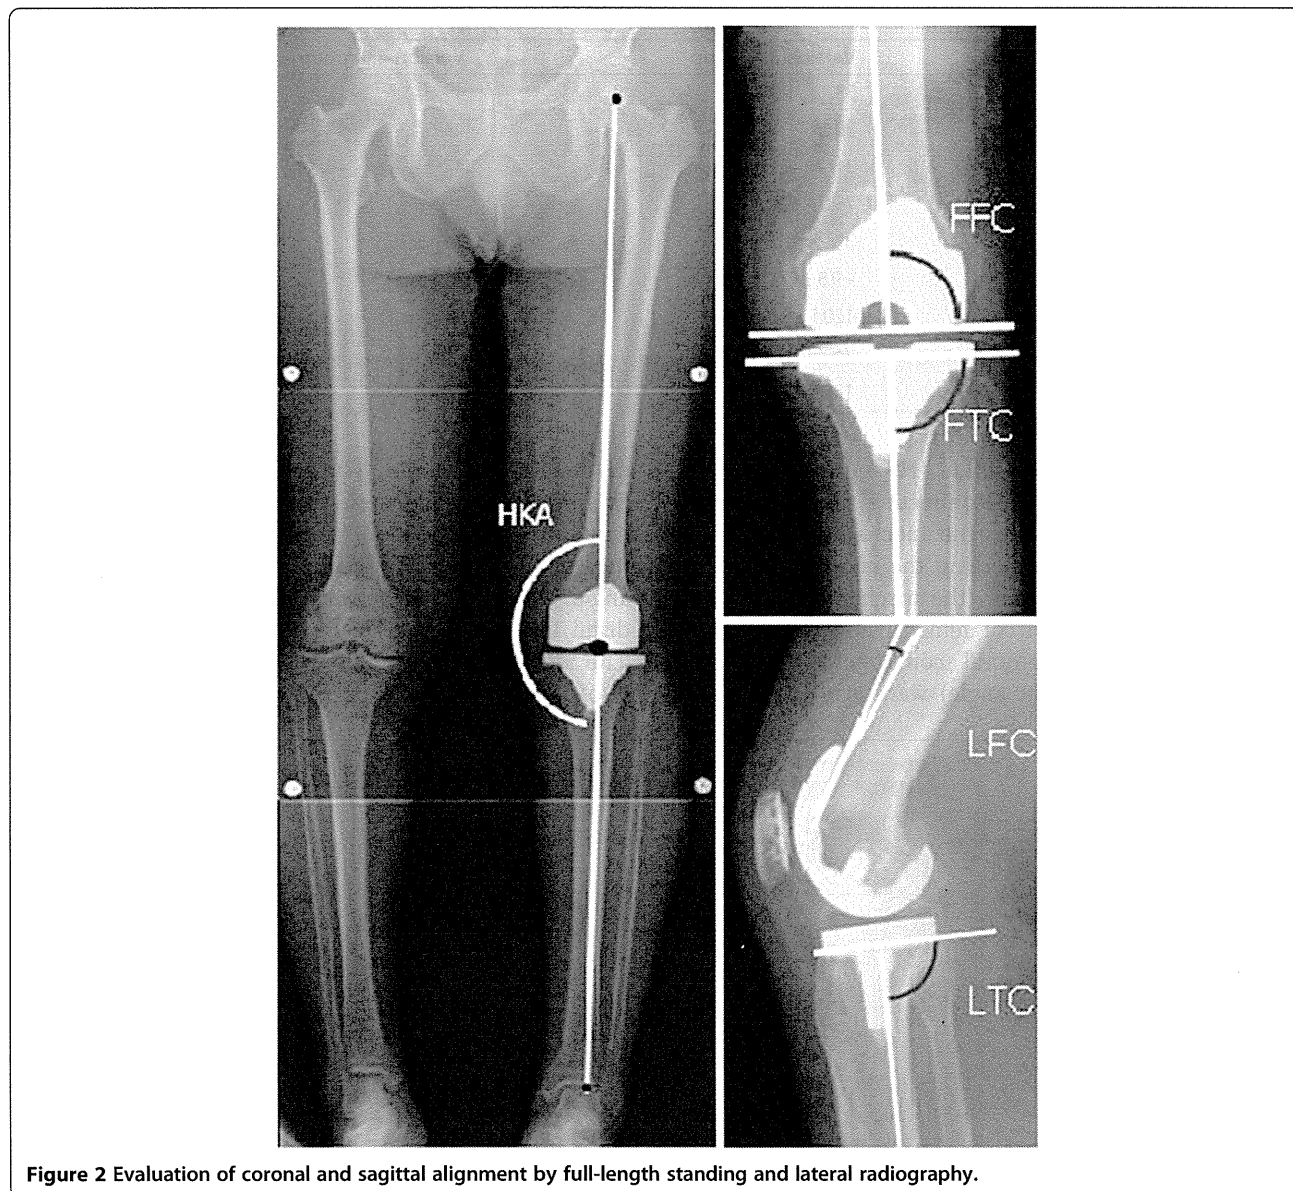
Evaluation of coronal and sagittal alignment by full-length standing and lateral radiography.
